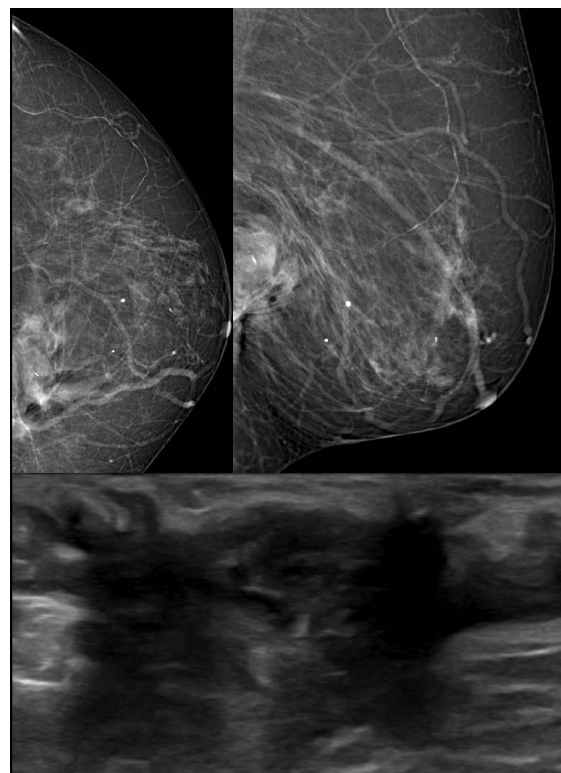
Mammography of left breast (MLO and CC view) shows an increase in size and radiographic density of the mass (a,b). US confirms an increased irregular mass with non-homogeneous ecostructure (c)
